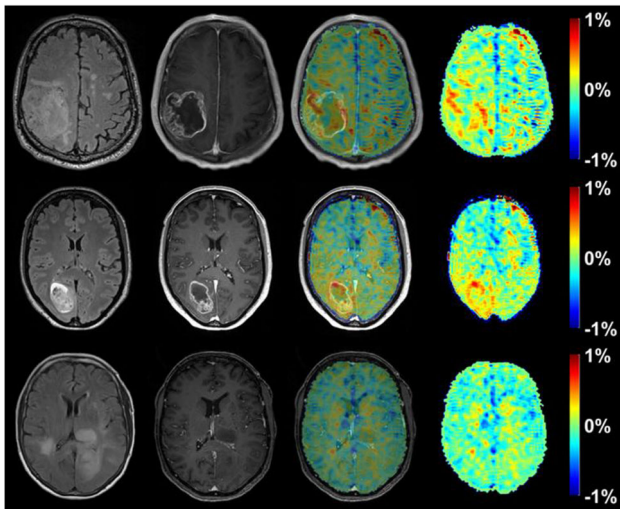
Three high grade brain tumor patient images (row 1-3), FLAIR (column 1), dynamic Gd enhanced (DCE) (column 2), dynamic glucose enhanced (DGE) CEST (column 4) and fusion of DGE and DCE (column 3), Herz et al. MRM 2019 doi: 10.1002/m
